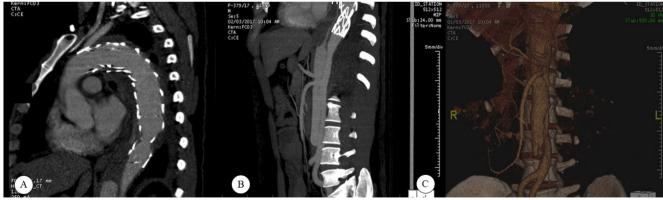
The images depict the follow-up computed tomography (CT) angiography. A & B) The CT angiogram shows a patent true lumen with no significant endoleak. B) The origin of the celiac and superior mesenteric arteries is from the true lumen. C) The image presents a 3D reconstruction.
